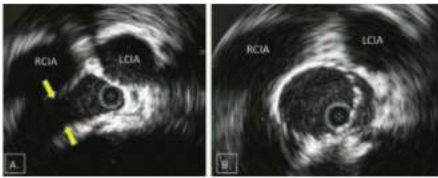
• Intravascular ultrasound is the most sensitive assessment tool for detecting May-Thurner compression of the left common iliac vein. A. The RCIA is lying directly over and compressing the left common iliac vein (between yellow arrows). B. Following stenting of the left common iliac vein, there is complete resolution of the compression by the RCIA.
